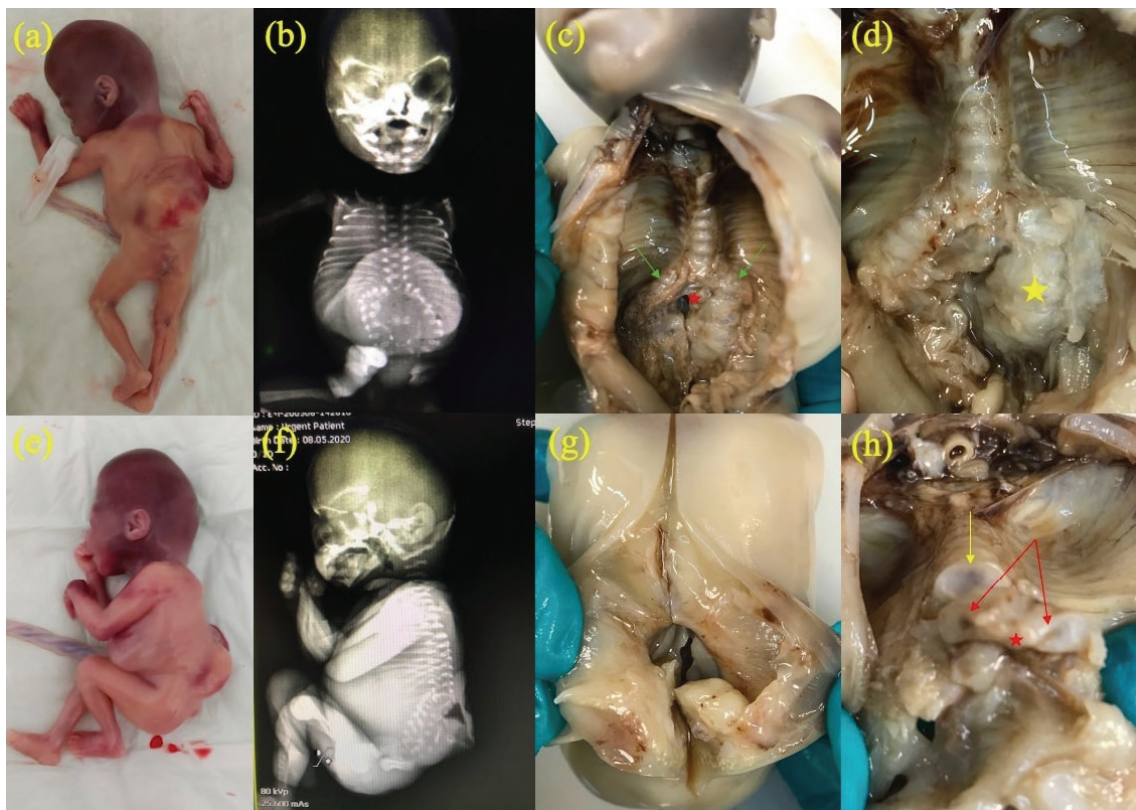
Fetal autopsy images and radiographic images of fetus with spine duplication and lipomyelomeningocele
